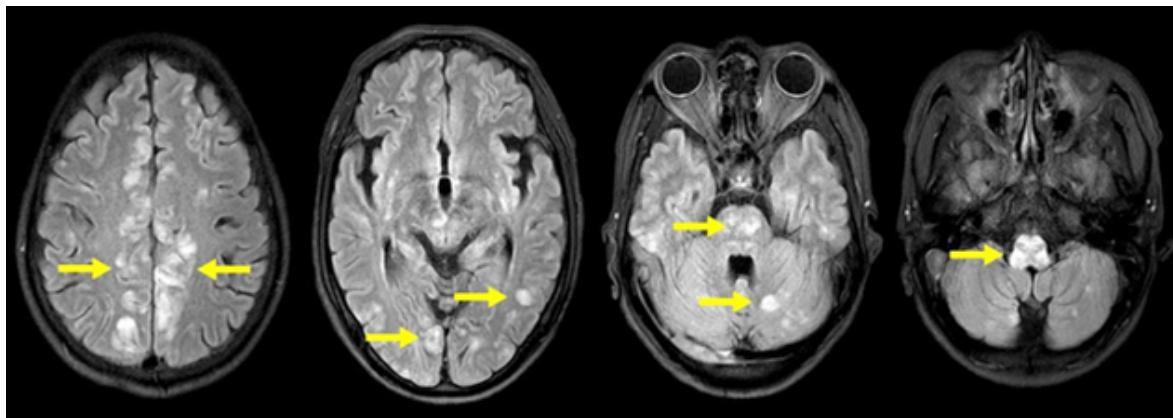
Fluid attenuated inversion recovery (FLAIR) images on brain magnetic resonance imaging (MRI). FLAIR images reveal multifocal high-intensity lesions suggestive of vasogenic edema in the brainstem and cerebellum, accompanied by medullary bulging. Gyral swelling is evident bilaterally in the cerebral hemispheres. These findings are indicative of hypertensive encephalopathy, potentially resembling the atypical variant of posterior reversible encephalopathy syndrome (PRES). Yellow arrows highlight the identified lesions.
